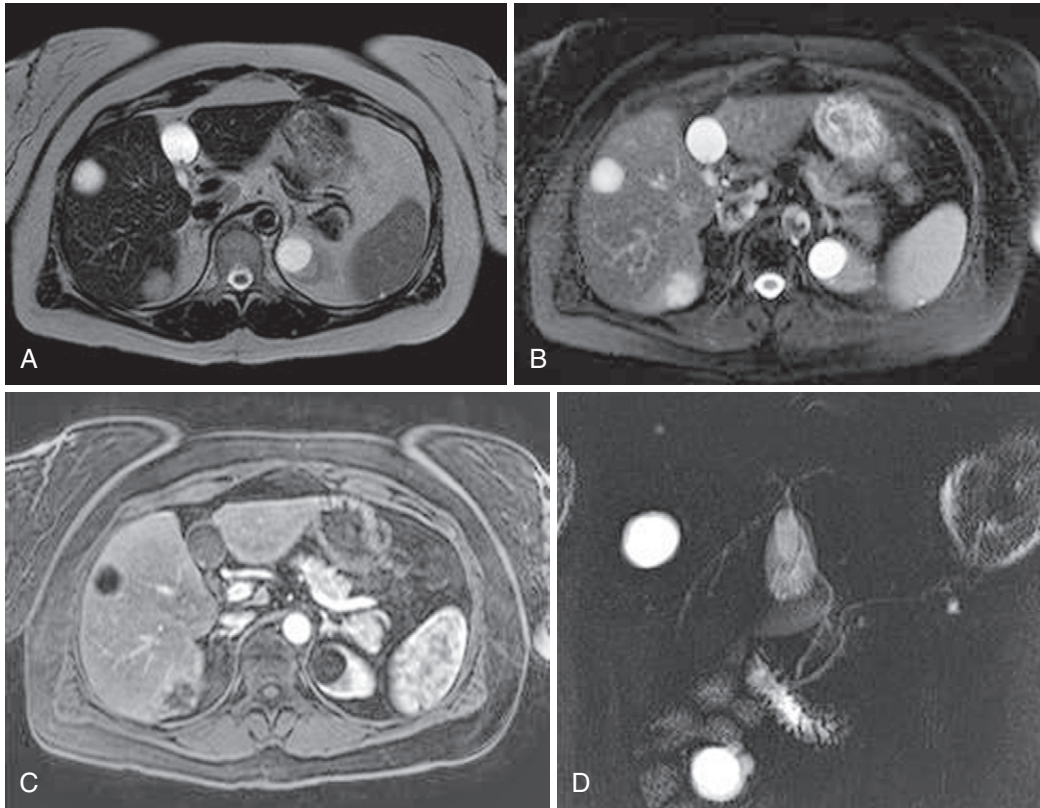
Ectopic gallbladder. T2-weighted (A), fat-suppressed T2-weighted (B), postcontrast fat-suppressed T1-weighted gradient recalled-echo (C), and coronal thick-slab MIP MRCP (D) images demonstrate an ectopic gallbladder in the fissure for the ligamentum teres.
